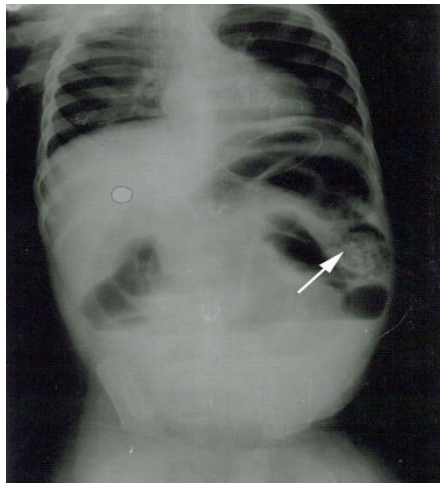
Plain x-ray abdomen (erect film) in a patient of Intussusception showing multiple air fluid levels with soft tissue density in left flank (arrow)
